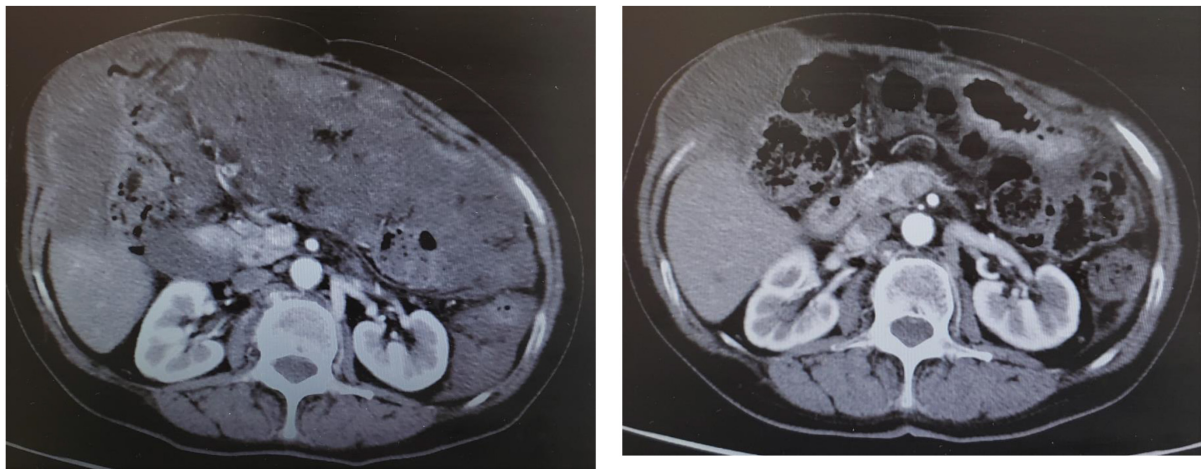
CT scan shows a big mass on the greater omentum before nivolumab treatment (left). After four cycles of nivolumab (240 mg/body) infusion, a PR response was obtained. The tumor mass removed by surgical excision showed no evidence of tumor cells.
